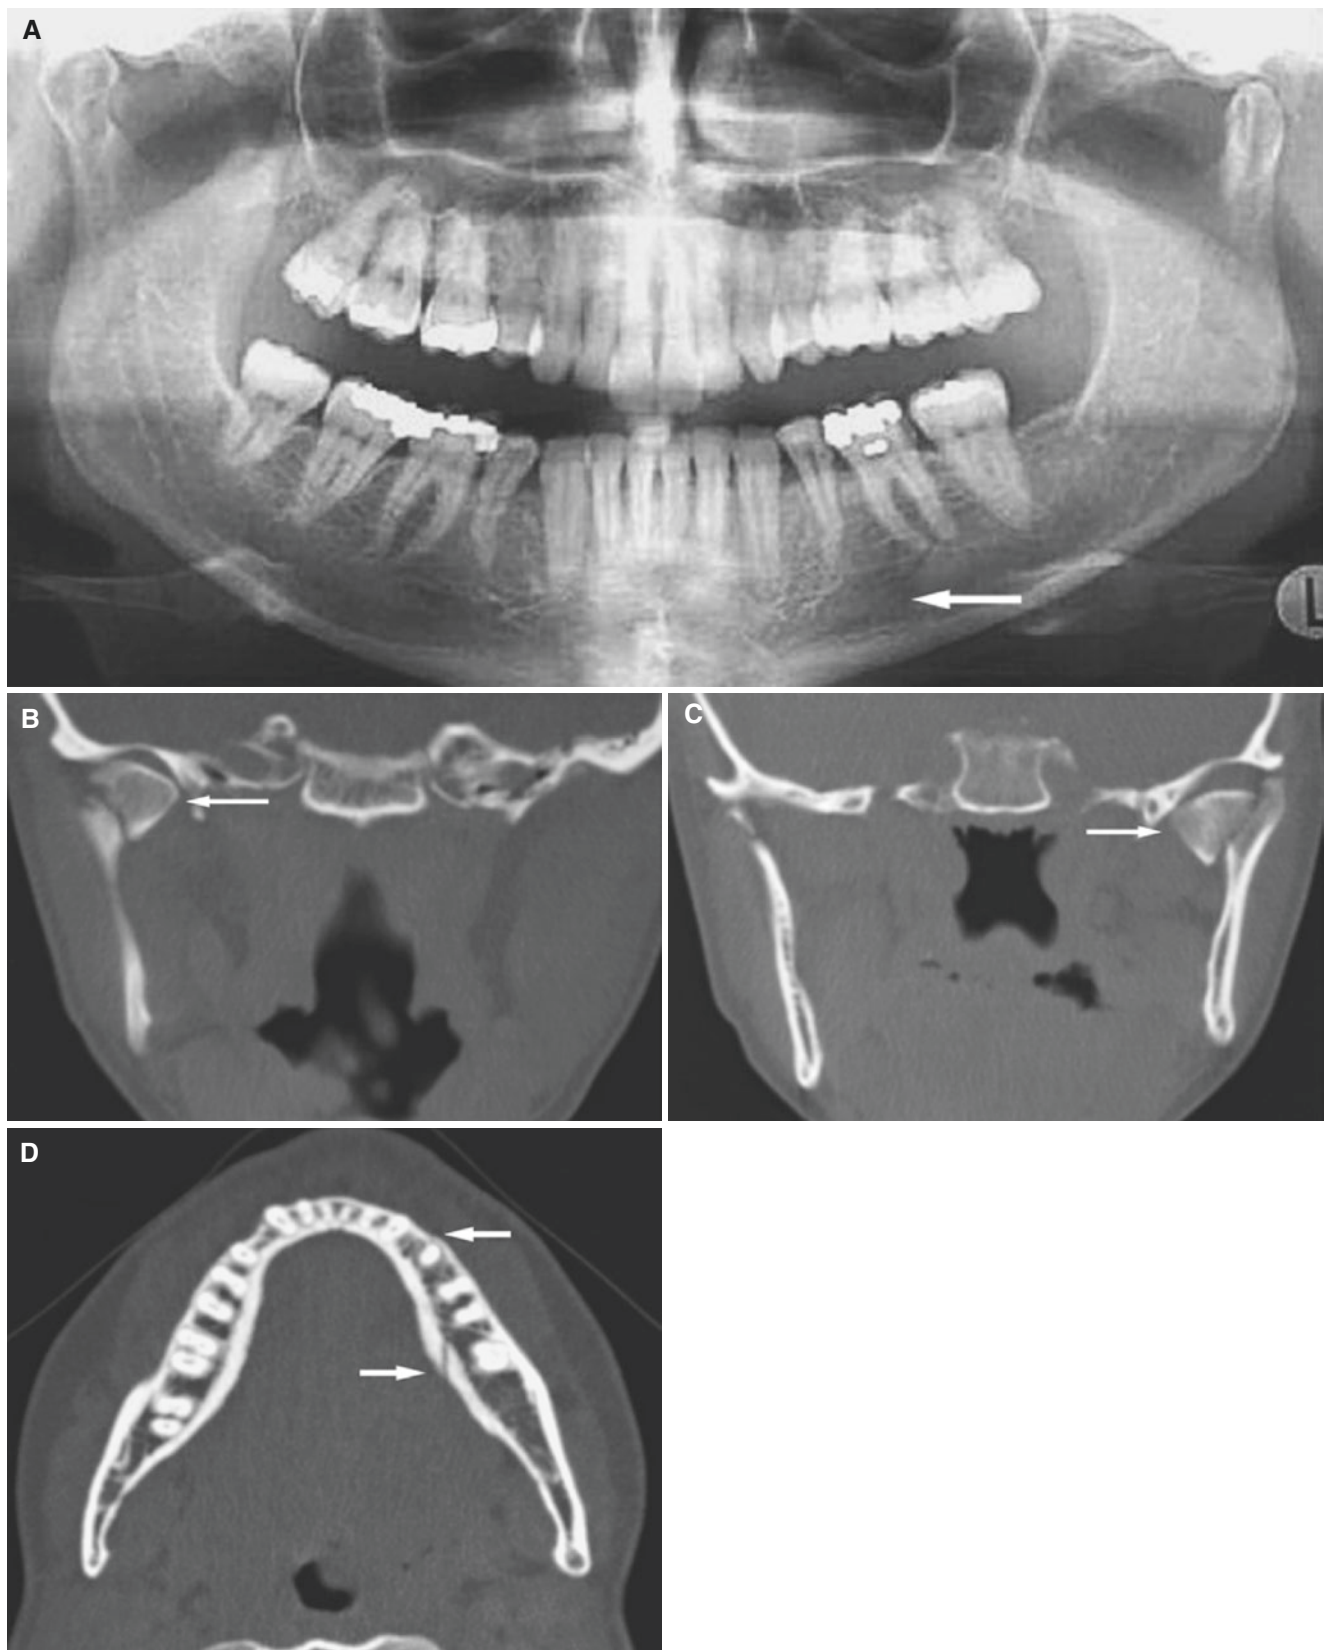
Mandibular bilateral neck and mandibular body fractures; 44-year-old female with trauma to the chin 3 weeks previously, but still some problems with dental occlusion (only tooth fractures diagnosed by clinical and intraoral radiographic examinations). (A) Panoramic view shows fracture of mandibular body (*arrow*) and suggests possible
